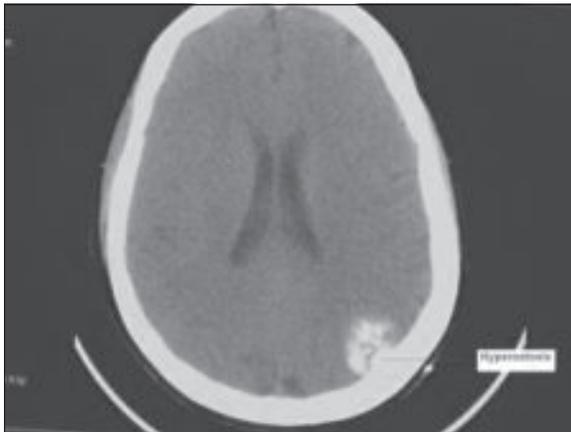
CT scan shows meningioma with bony hyperostosis.jpg
